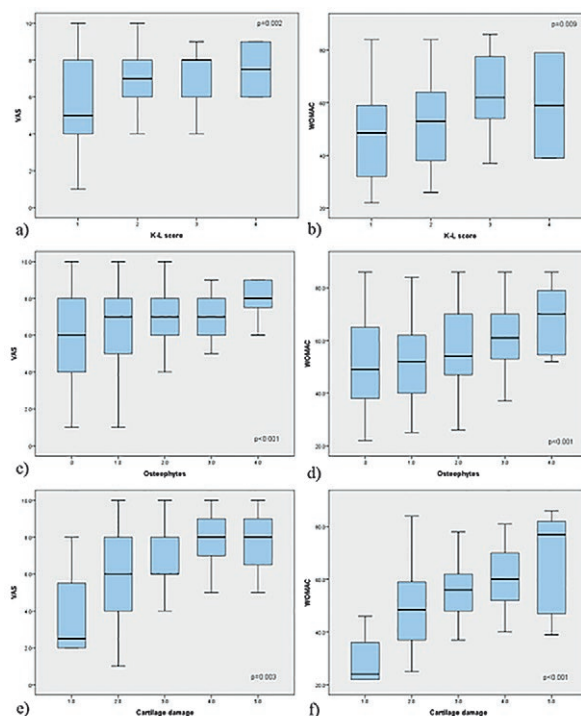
Comparison of pain intensity registered as VAS and WOMAC scores between different categories of radiographical – (a and b) K-L score – and ultrasonographical findings – (c and d) osteophytes and cartilage damage (e and f).
